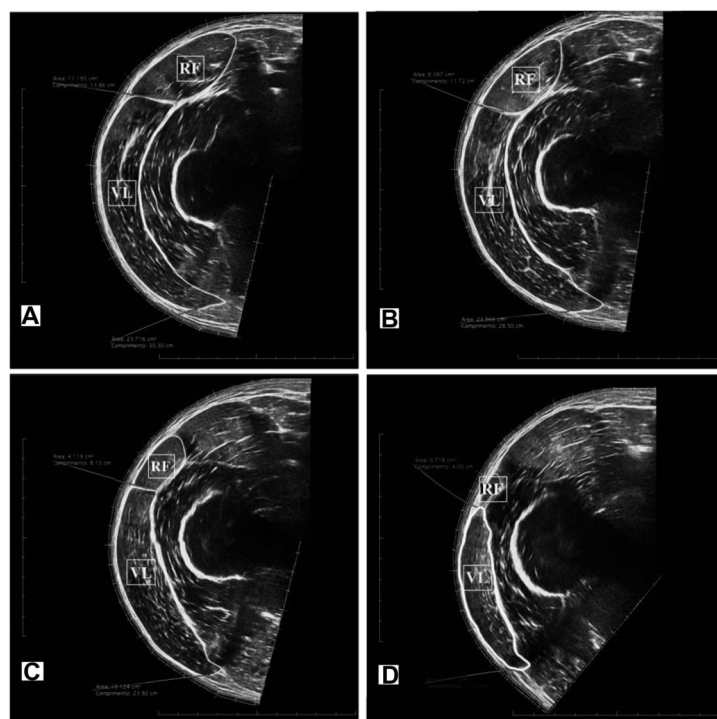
Ultrasound images and cross-sectional areas (CSAs) at 40% (A), 50% (B), 60% (C), and 70% (D) of femur length. RF = rectus femoris and VL = vastus lateralis.
